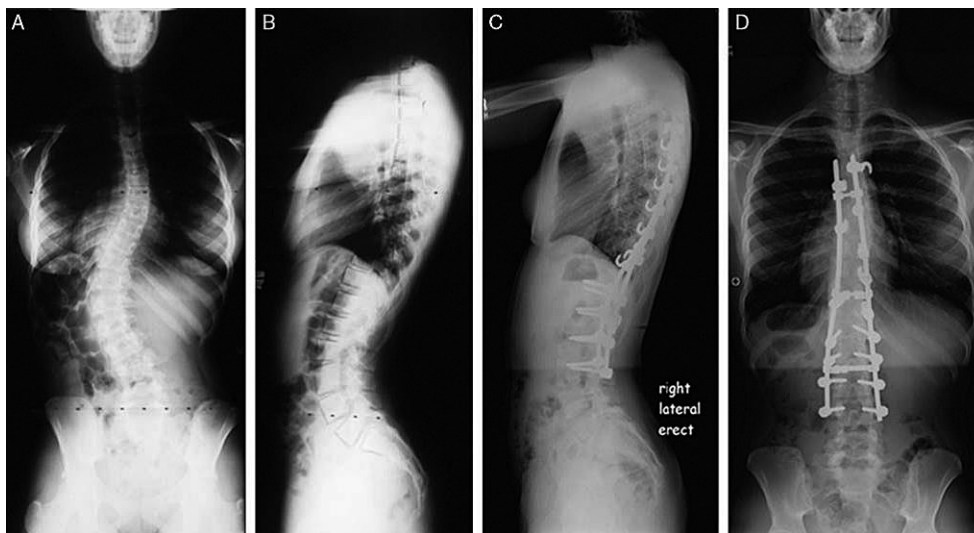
Preoperative spine x-rays of a patient with hybrid instrumentation
